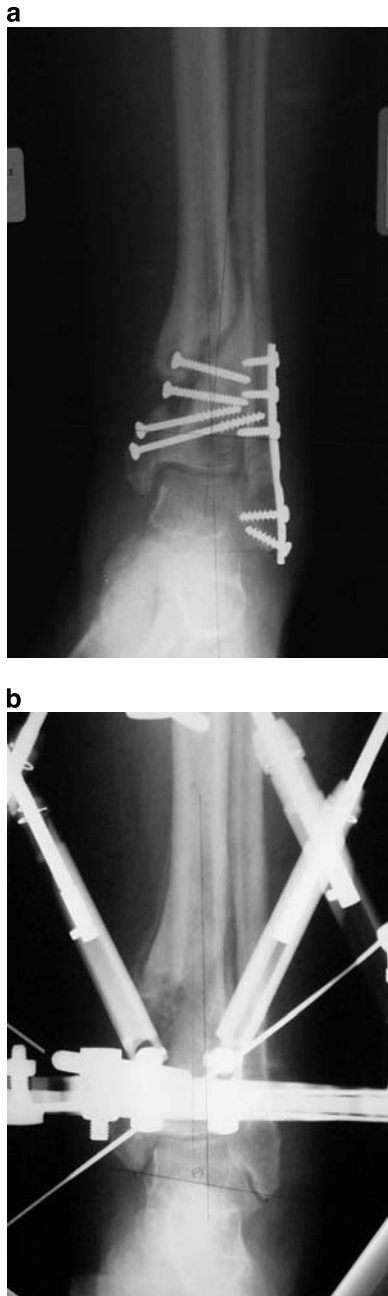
a AP radiograph showing relative shortening of the tibia and a nonunion. b After gradual lengthening and deformity correction of the tibia with an Ilizarov/Taylor Spatial Frame
